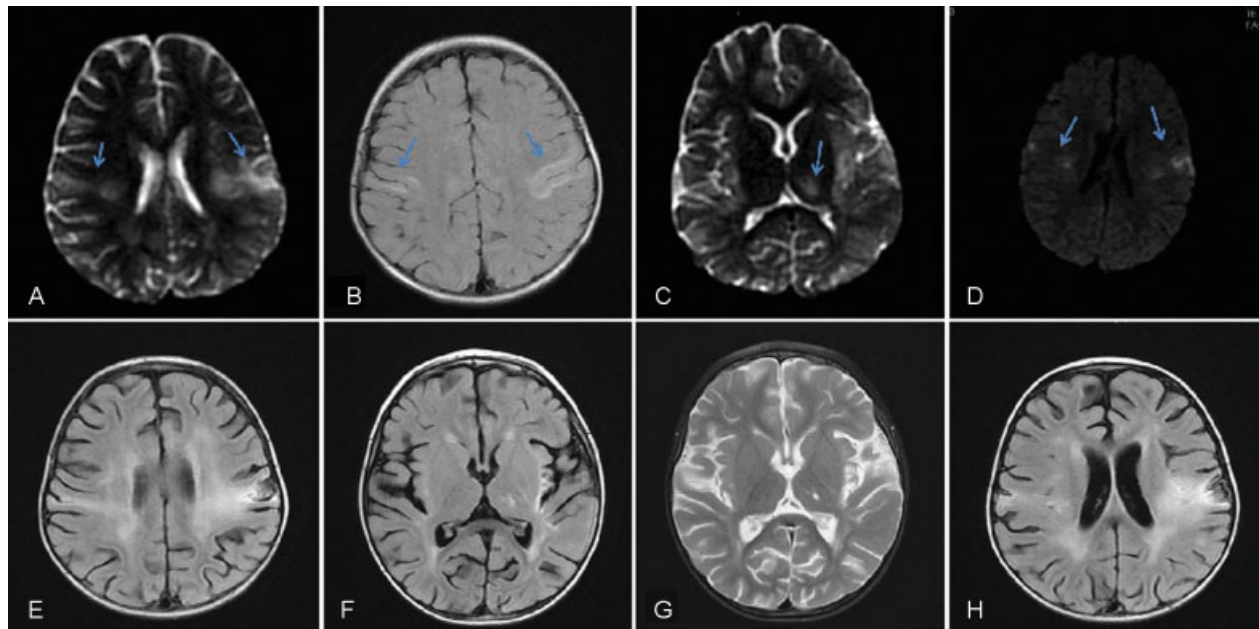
Magnetic resonance imaging (MRI) findings of a patient who developed herpes simplex encephalitis (HSE) followed by anti-N-methyl-D-aspartate (anti-NMDAR) encephalitis. (A–D) The MRI findings during the first week of HSE. (A, B) Increased T2 and T2-FLAIR signal were demonstrated in the left medial temporal lobe, right insula, posterior basal ganglia, and bilateral opercular regions, and (C, D) increased signal in diffusion-weighted images. Arrows signify increased signal (hyperintensity). (E–H) The MRI obtained during admission for anti-NMDAR encephalitis, 1 month after HSE onset, showed no additional changes other than the interval evolution of areas of encephalomalacia in opercular regions and hippocampal atrophy.
